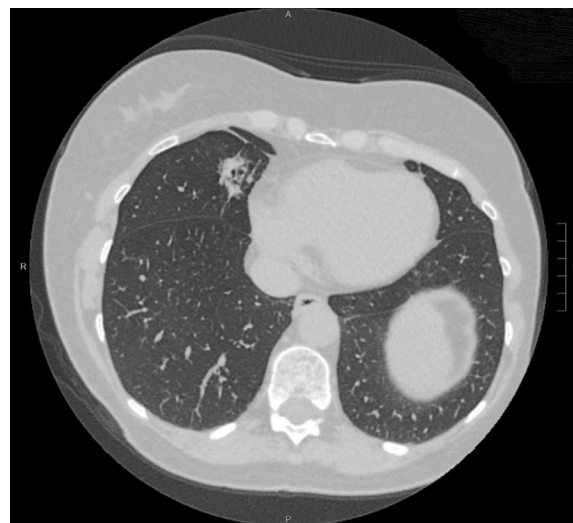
Preoperative coronal computed tomography of right middle lobe adenocarcinoma
